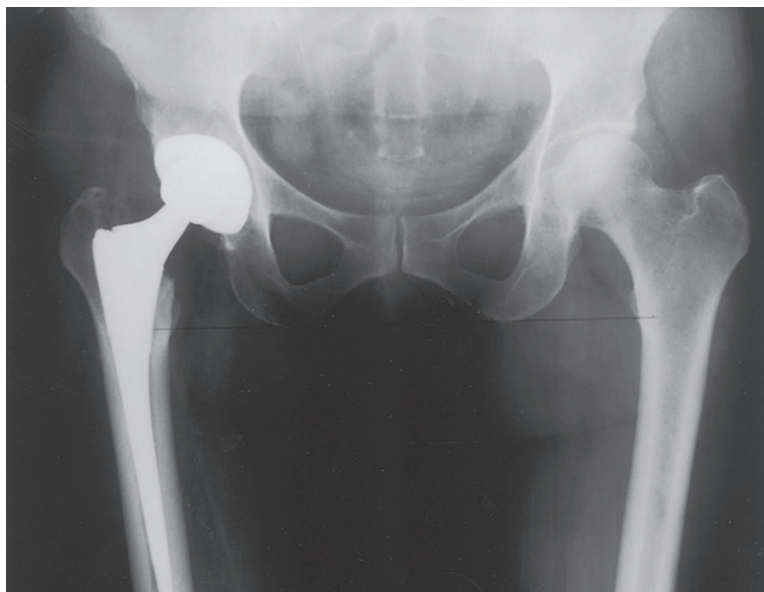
Radiograph of the right hip with total hip arthroplasty used nowadays
